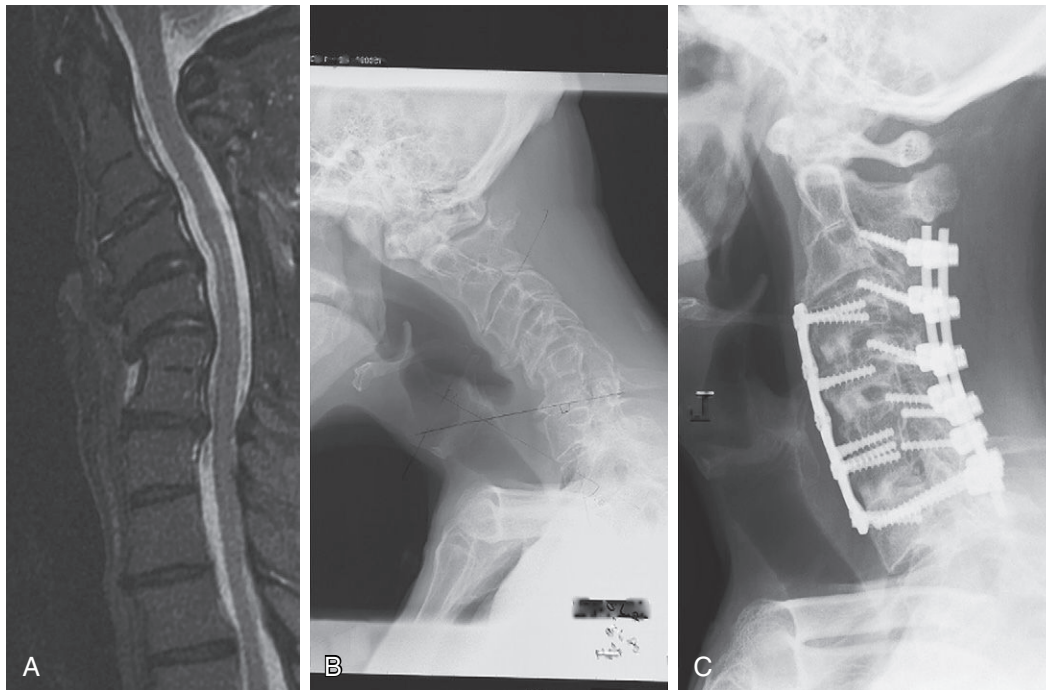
Sagittal magnetic resonance image (MRI) (A) and lateral radiograph (B) of a 60-year-old man with a prior laminectomy and Klippel-Feil malformation at C2-C3 shows progressive fixed kyphotic deformity. C, Lateral postoperative radiograph after a three-staged procedure, including posterior release, C3-T1 posterior spinal fusion, and C3-T1 correction to anterior cervical discectomy and fusion, shows marked reduction of fixed deformity. (From Chi JH, et al. Complex deformities of the cervical spine. *Neurosurg Clin N Am.* 2007;18(2):295-304.)
